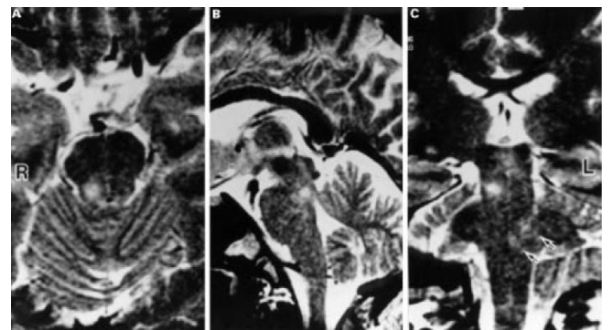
(A) Axial view, (B) sagittal view and (C) coronal magnetic resonance imaging of a patient with rhombencephalitis causing urinary retention and horizontal diplopia. T2-weighted images show a hyperintense focus in the right dorsolateral tegmentum of the rostral pons and arrows indicate amorphous lesions (C). (Reproduced from Sakakibara et al., 1998.)
